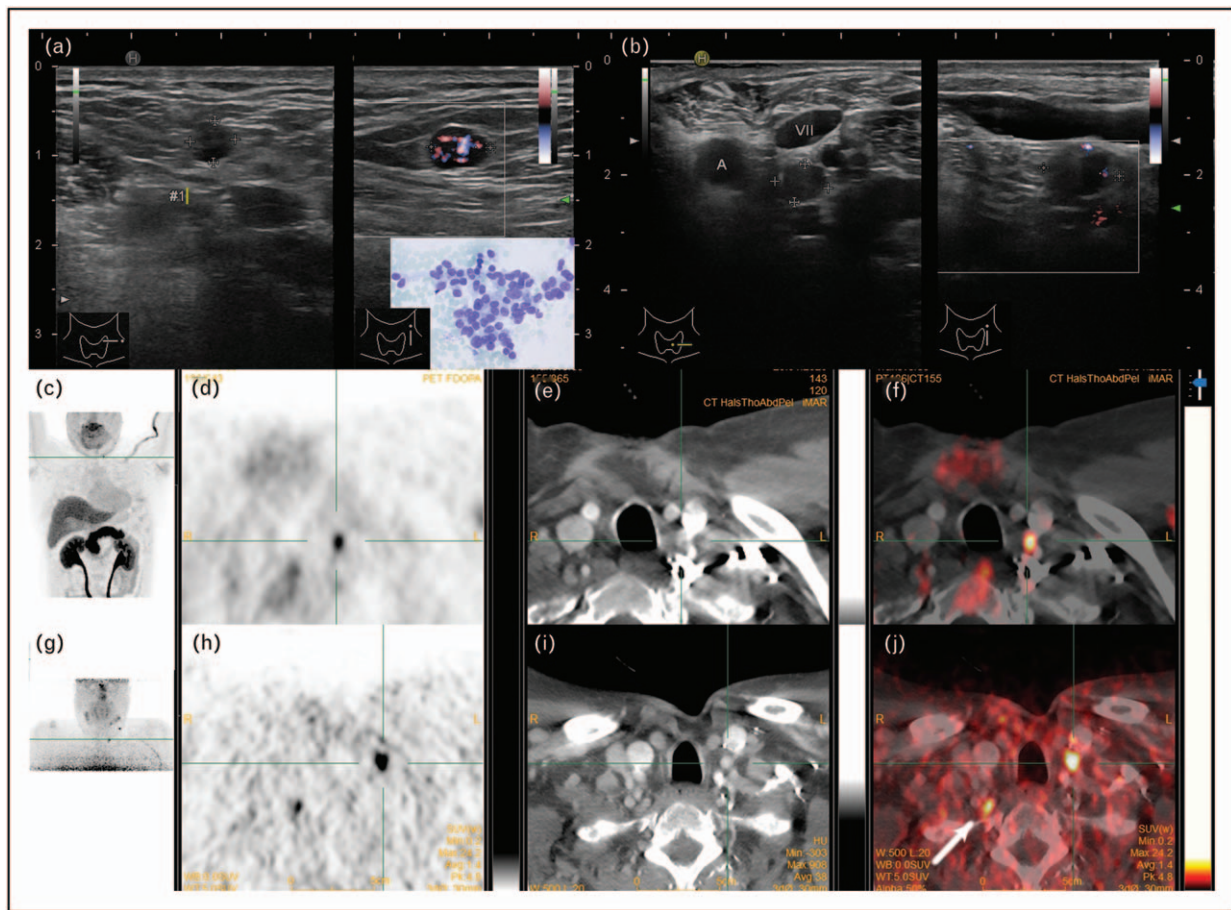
A 51-year-old man with medullary thyroid cancer pT1a (4 mm) pN1. Total thyroidectomy with left lateral LN dissection in 2003. In 2011, [^{18}F]FDG-PET including CT-CT showed two enhancing but FDG-negative LN metastases, which were confirmed on surgery. Rising serum calcitonin (25.1 pmol/l). Ultrasound in October 2019 showed a 5 mm hyperperfused LN (a). FNB revealed malignant cells (a), calcitonin from the aspirate was 3850 pmol/l. [^{18}F]FDOPA-PET in Aarhus/Denmark (c–f) revealed two foci: the known LN metastasis and a focus in the left central neck. Subsequent [^{68}Ga]DOTATOC-PET with a dedicated CE-CT of the neck with arms down (g–i) at our center confirmed both foci and allowed us to localize the central cervical lesion by US (b). The prevertebral focus (arrow in j) is physiological tracer uptake in the right stellate ganglion. CE-CT, contrast-enhanced CT; FNB, fine needle biopsy; LN, lymph node.
